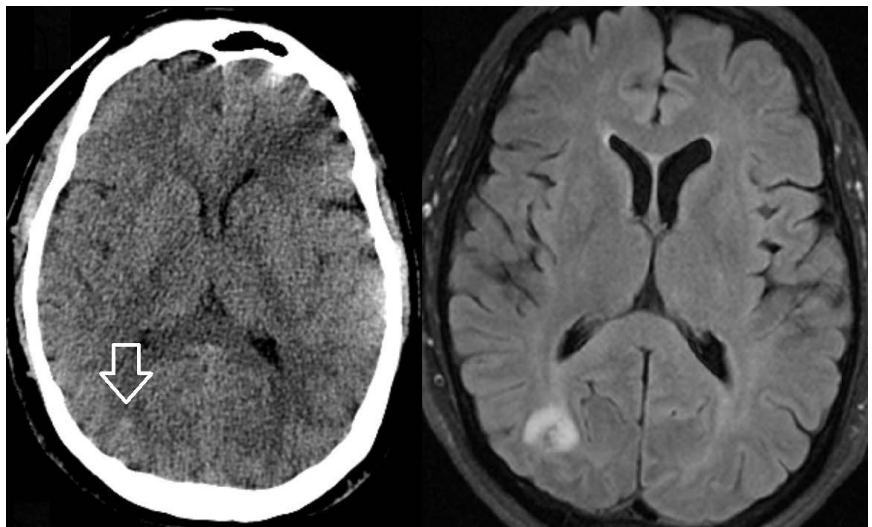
Infectious etiology—Staphylococcus endocarditis. A 60+ y/o who presented with fevers, headache, rash, and weakness for a day secondary to severe sepsis and methicillin-sensitive Staphylococcus aureus bacteremia and a small vegetation over the prosthetic aortic valve. Hyperdensity in the right parietal area on head CT (arrow) with corresponding changes on the FLAIR sequences (right).
